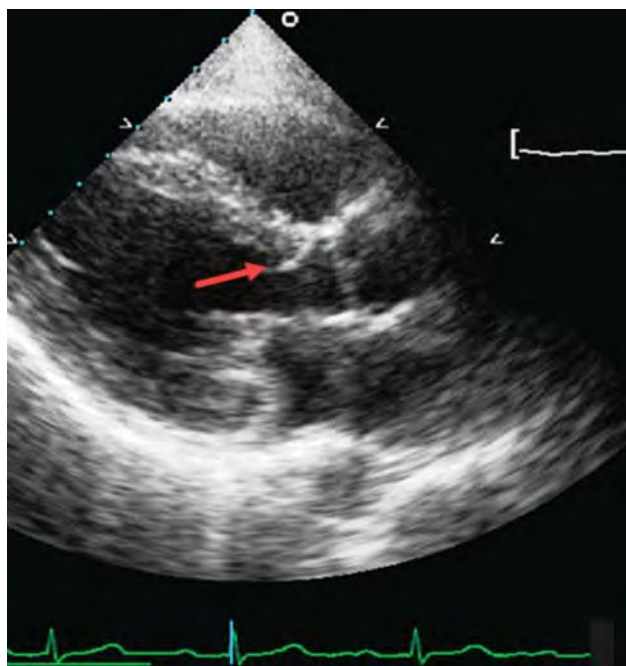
Parasternal long-axis view showing subaortic membrane.
